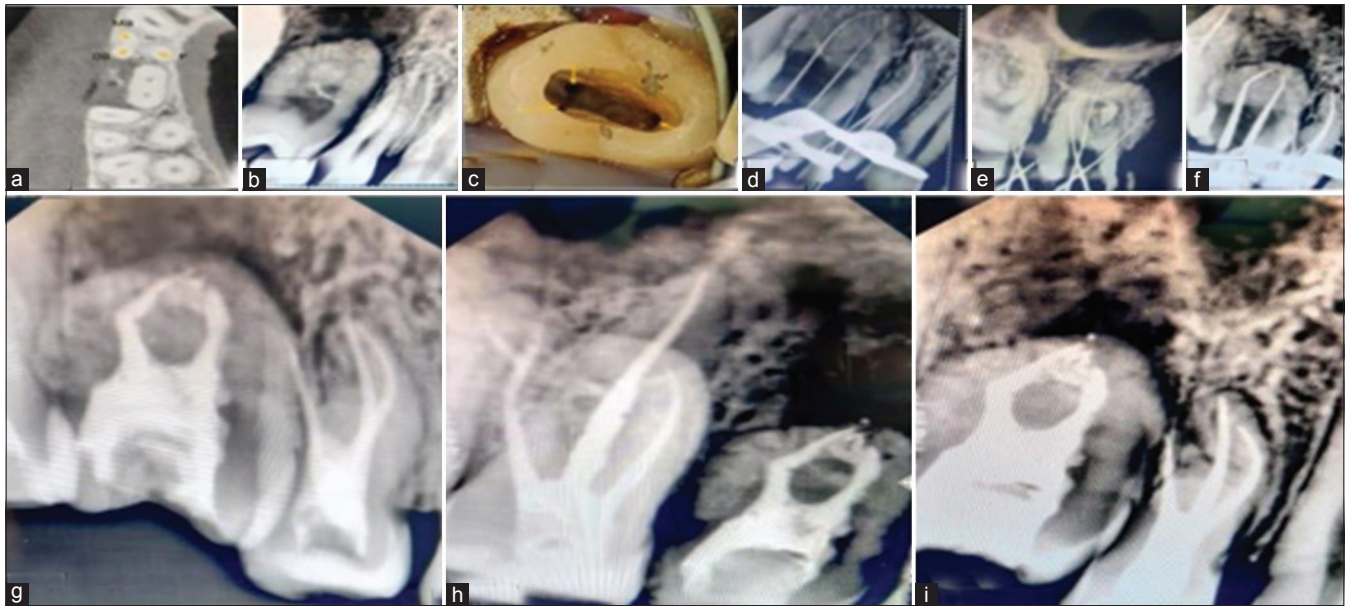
(a) Cone-beam computed tomography image of three-rooted first premolar, a rotated second premolar, and a maxillary first molar (b) pre-operative radiograph (c) access opening shows three separate canals (d) working length determination of 14, 15 (e) working length determination for 16 (f) radiograph shows master cone (g and h) radiograph after obturation of the first, second maxillary premolar, and first molar (i) Radiograph shows post-obturation
